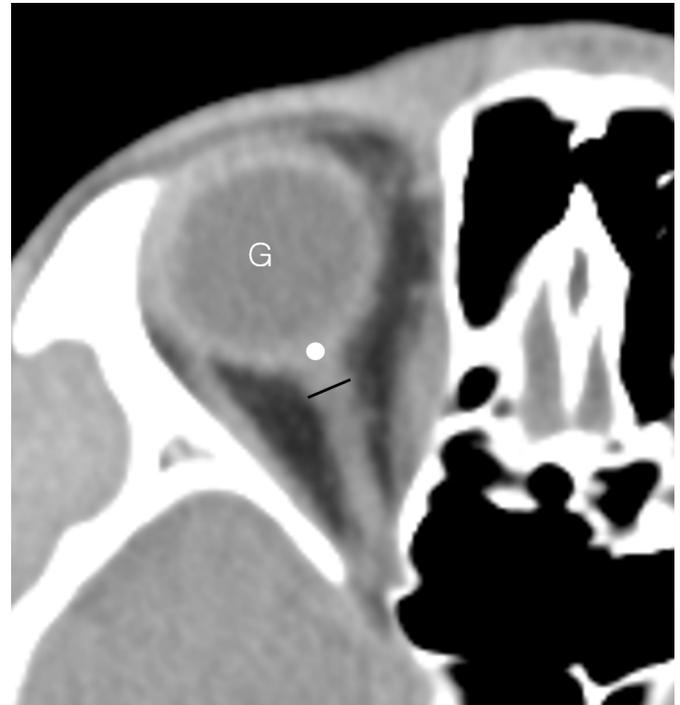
Use of axial non-contrast computed tomography to measure the optic nerve sheath diameter (ONSD). G, globe.
